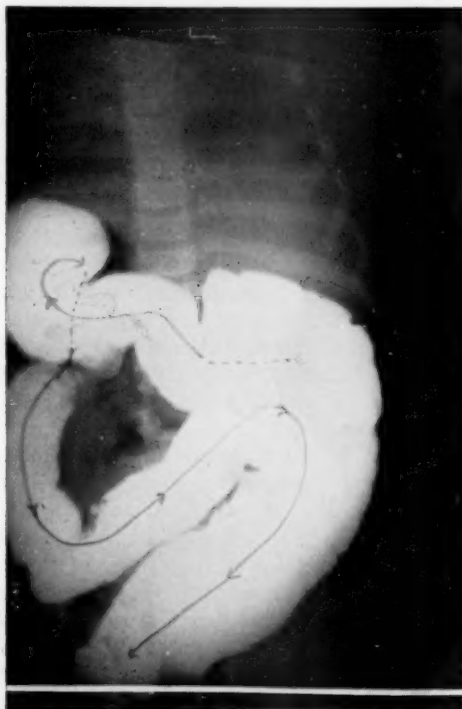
Initial barium enema showing extent of colonic dilatation, lack of haustral markings, right pelvic colon and course of injected barium. Because of overlapping, the position of the cecum is not defined on the x-ray films, but was easily seen in oblique positions on fluoroscopy.
